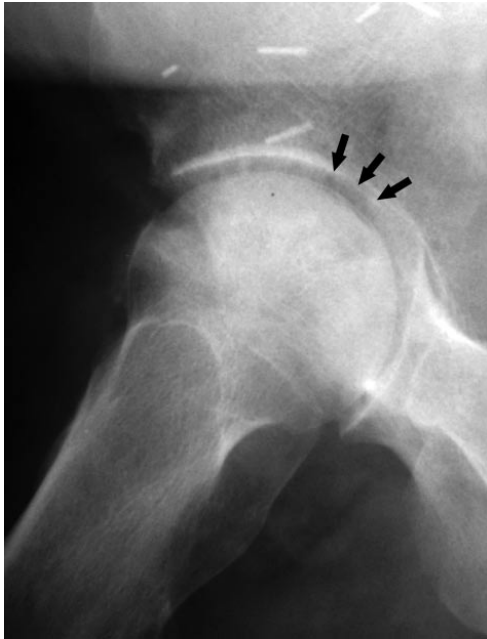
Frog-leg lateral radiograph of the femoral head in a 46-year-old man with Steinberg stage III osteonecrosis. Note the crescent sign (arrows), a hallmark of osteonecrosis caused by the discrepancy in densities of the femoral head due to subchondral bone collapse.
